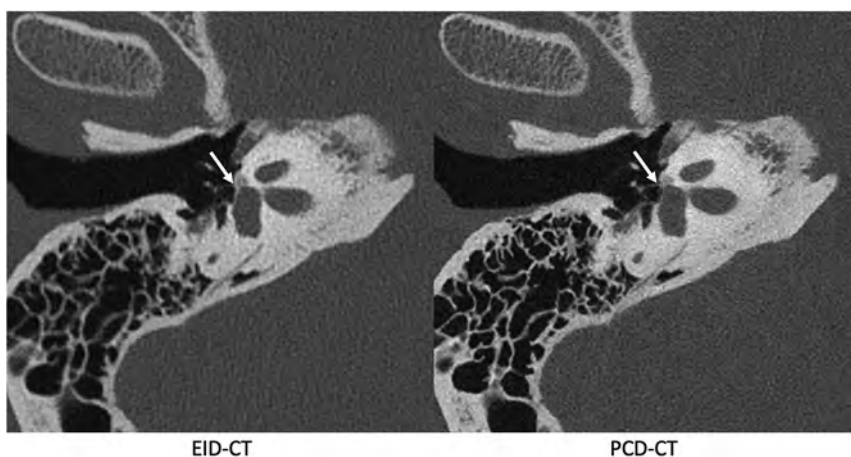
Images reformatted along the long axis of the stapes in a patient with fenestral otosclerosis shown on EID-CT (left) and conventional PCD-CT (right) images. The arrow points to the insertion of the anterior crus of the stapes into the region involved by otosclerosis. These additional reformatted images were generated by a nonreviewer radiologist to demonstrate certain anatomic features but were not used by the readers to score image quality.
